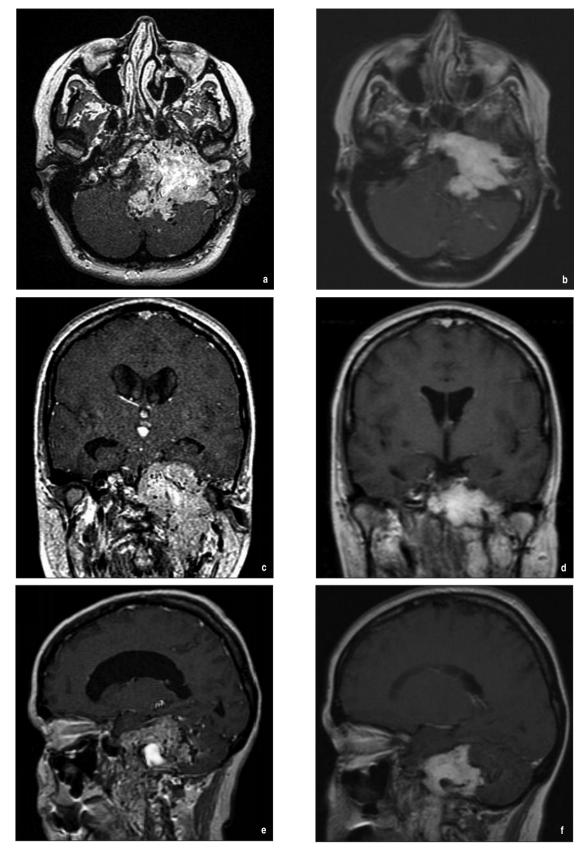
a,c,e: Axial, coronal and sagittal T1MRI with contrast images obtained just before; and b,d,f: Axial, coronal and sagittal T1 MRI with contrast images obtained just 14 months after the completion of the RT.
